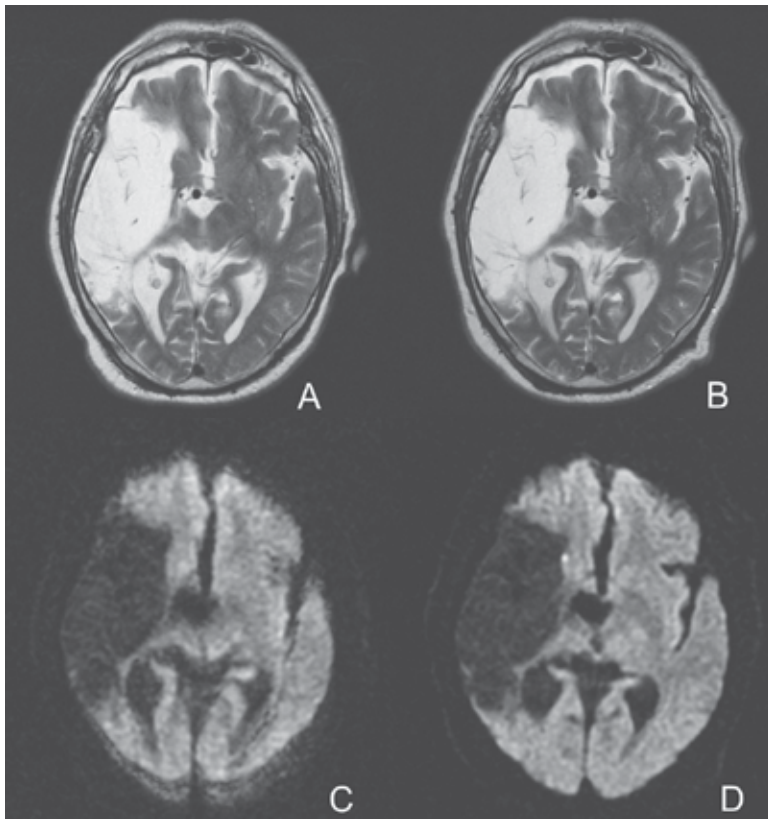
Patient 27, male, 73 years old with right carotid artery occlusion and stenosis of the left carotid artery estimated at 70% by DSA (not shown). Before CAS: T2 sequence (A) shows old infarction in the territory of the right MCA and diffusion sequence (C) without recent ischemia foci. The patient underwent DSA of both common carotid arteries and CAS of the left. In the MRI study, the T2 sequence was unchanged after CAS (B) and the DWI sequence showed NF in the head of the caudate nucleus to the right (D)
